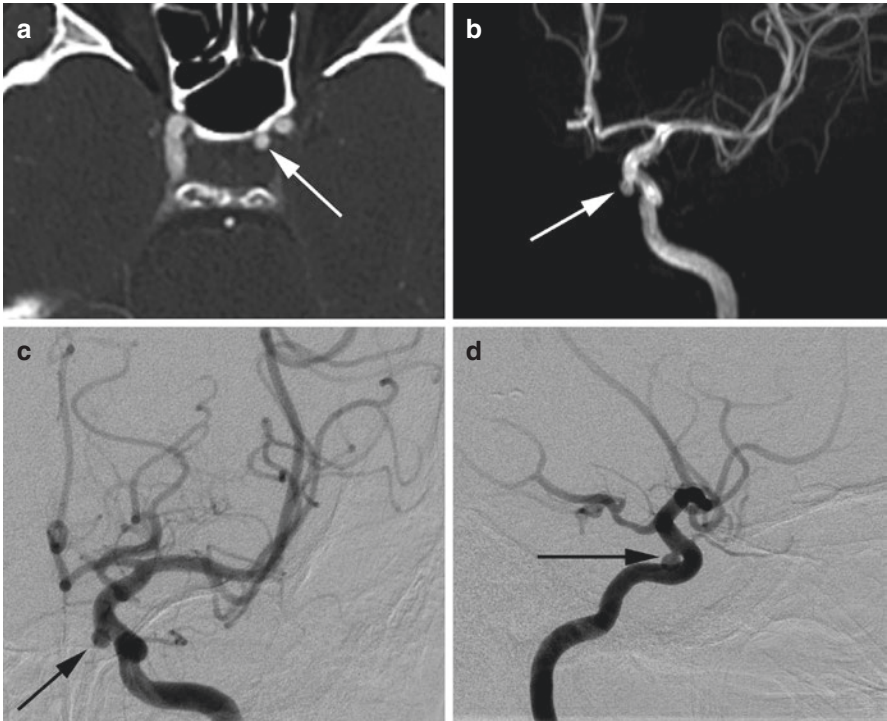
Carotid cave aneurysm. Patient with a left carotid cave aneurysm. CTA (a), time-of-flight MRA 3D reformat (b), DSA frontal (c) and lateral projections (d) show a small ICA aneurysm involving the carotid cave (arrow). A carotid cave aneurysm is intradural, but may appear extradural due to inferomedial projection into the cavernous sinus
